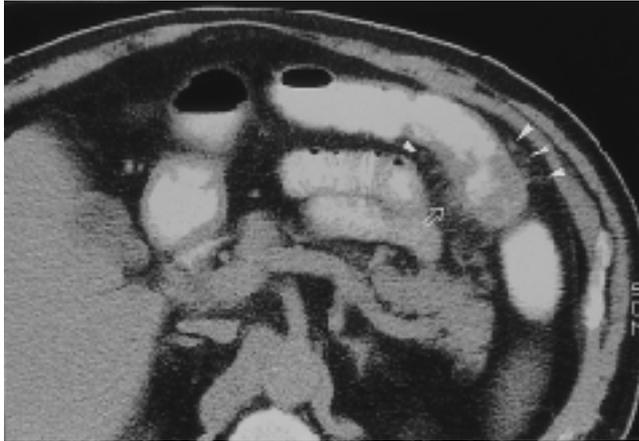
The gastrografin enema CT scan shows irregular wall thickening at the splenic flexure of the colon and pericolic infiltration(open arrow). Three clustered nodes(arrowheads), each less than 1cm, are seen(N1). Pathologic examination revealed that one metastatic lymph node of 12 dissected pericolic lymph nodes(N1).
